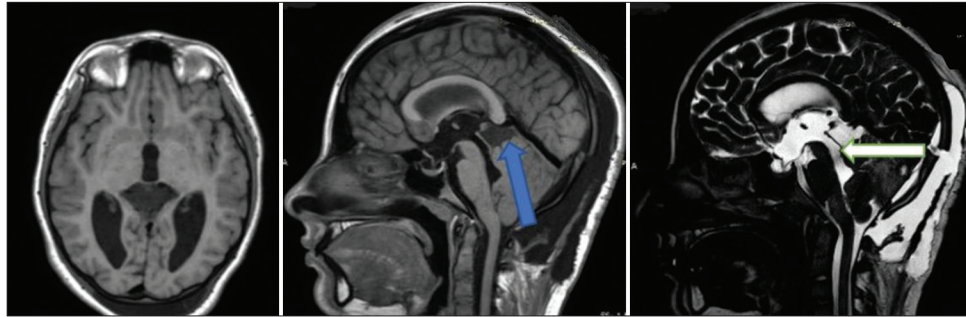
Day 6 postoperative MRI showing reduction in cyst size (blue arrow) and positive flow of CSF through the aqueduct (white arrow).
